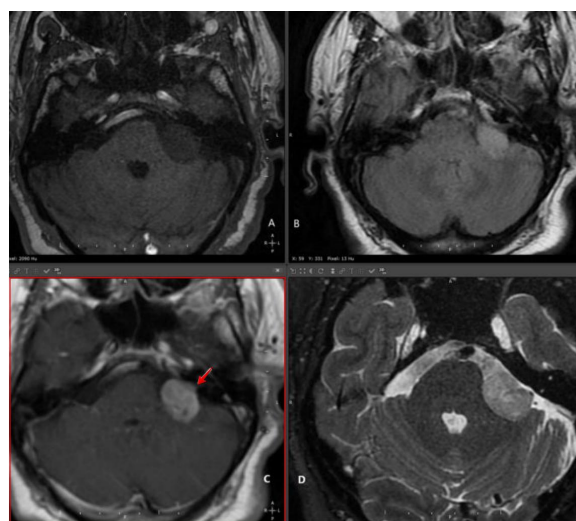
Initial MRI scan. Axial T1A (a), FLAIR (b), post-contrast T1A (c), and TSE T2A (d). Extension into the intracanal segment of the left internal auditory canal (red arrow) [14]
